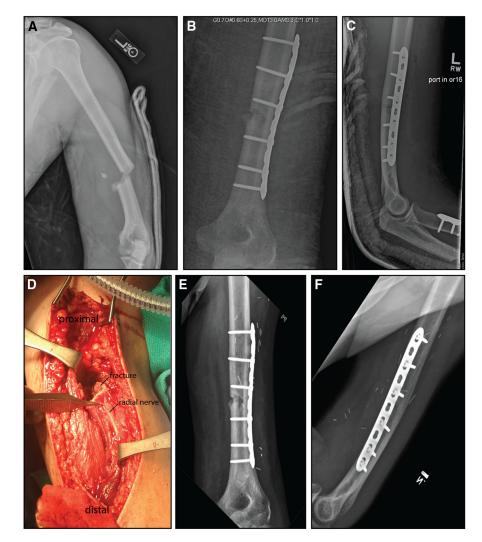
(A) Preoperative anterior-posterior radiograph showing a transverse humeral shaft fracture with moderate comminution. (B, C) Portable anterior-posterior and lateral radiographs taken in the operating room demonstrate anatomic alignment and fixation. (D) Intraoperative photograph demonstrating the radial nerve transection at the level of the fracture. (E, F) Radiographs at 3-month follow-up reveal a partially healed fracture with intact implants.
